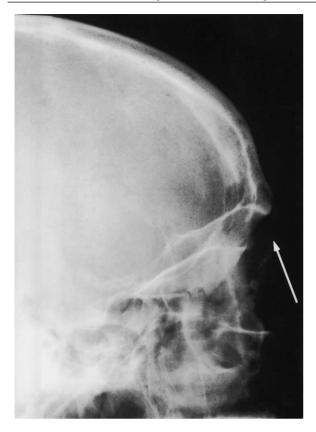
Radiograph lateral view of skull, revealing eroded anterior wall to frontal sinus.
